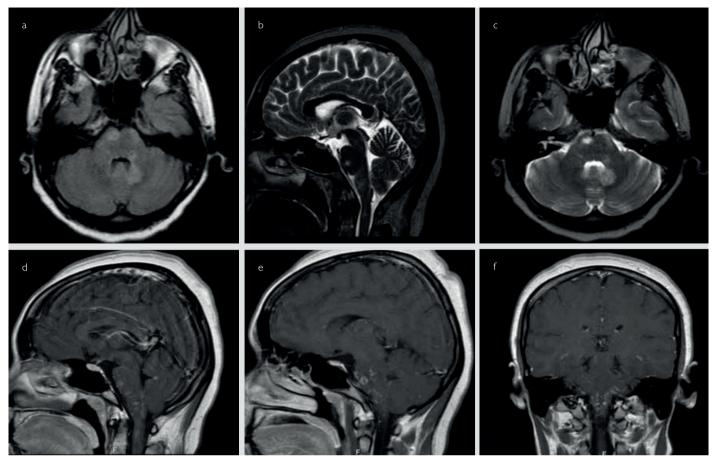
a-f. Brain MRI lesions of the first case. Axial FLAIR (a), Sagittal T2 (b), Axial T2 (c) weighted MR images show hyperintensities in the brainstem. Sagittal post contrast (d, e), Coronal T1 post contrast (f) weighted MR images show contrast enhancement pattern of first case
